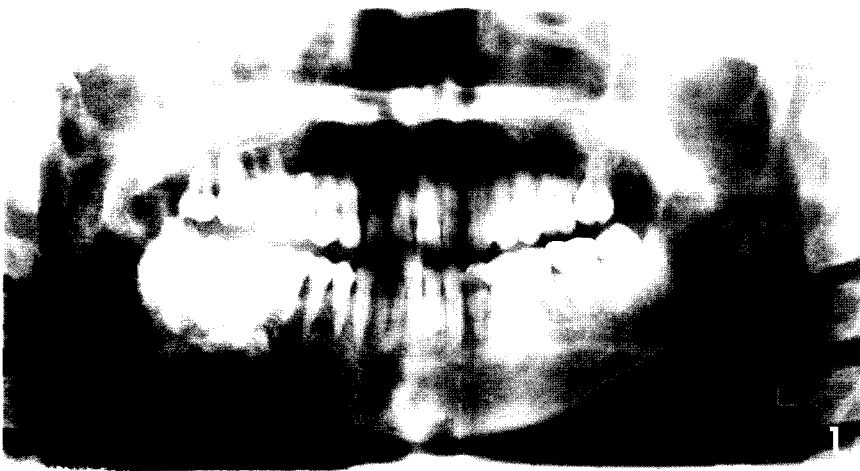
A panoramic radiograph showed numerous ill-defined radiolucencies throughout the whole mandible including both mandibular condyles and coronoid processes.
